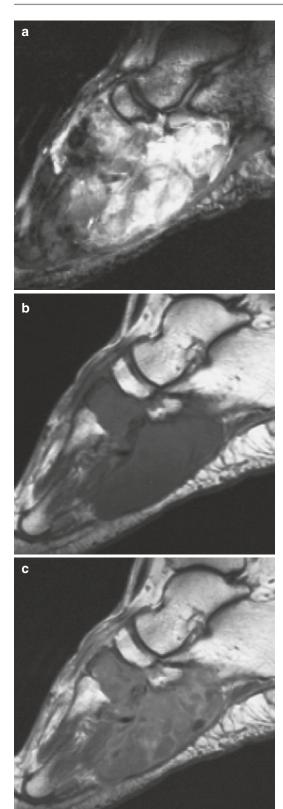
Synovial sarcoma of the foot in a 37-year-old man. (a) Sagittal gradient-recalled echo $T2^*$ -weighted MR image. (b) Sagittal spin-echo T1-weighted MR image. (c) Sagittal spin-echo T1-weighted MR image after gadolinium contrast injection. Synovial sarcoma is generally hypointense on a T1-weighted image (b) and hyperintense on a T2-weighted image (a). Large lesions such as this one are usually heterogeneous and may show internal septation (a). Marked enhancement is correlated to the extensive vascular supply of these tumors (c). Bone invasion is less frequent (5–30%), but can be quite important. The sole of the foot is a common localization of synovial sarcoma in young adults
